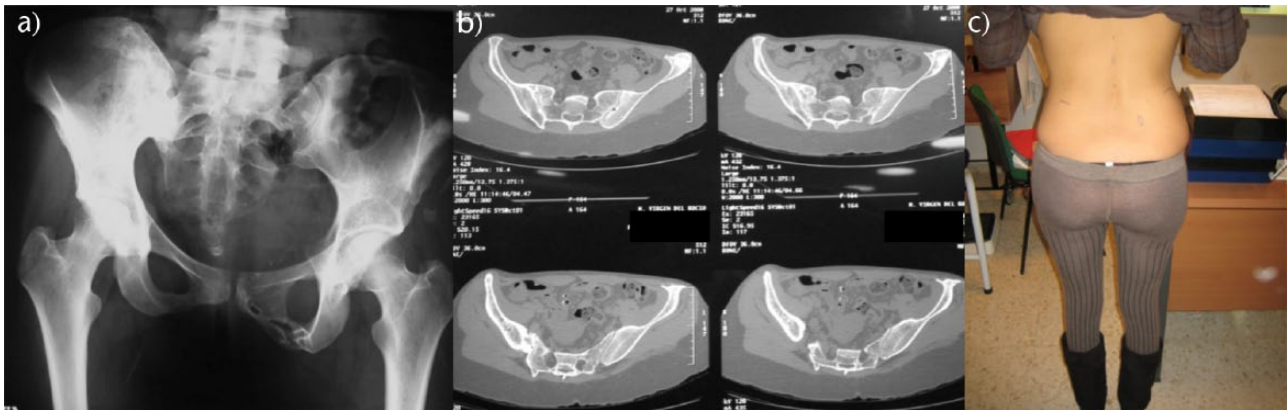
Type IB complex instability: a) preoperative radiograph; b) preoperative CT scan (axial views); c) leg-length discrepancy > 3 cm.
